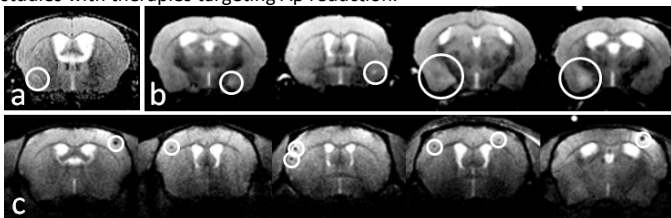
Circumscribed above are representative examples of ARIA-E in T2-weighted images (a-perivascular ring pattern, b-variable size/severity/diffuseness) and ARIA-H in T2*-weighted images (c). These images were chosen to exemplify various manifestations of the several patterns of abnormalities.
